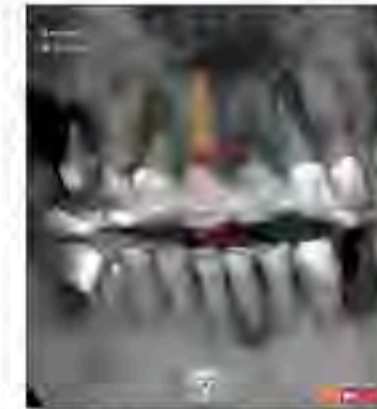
Three-dimensional imaging modalities afforded by a cone beam computed tomography (CBCT) are essential for proper diagnosis and treatment planning.
